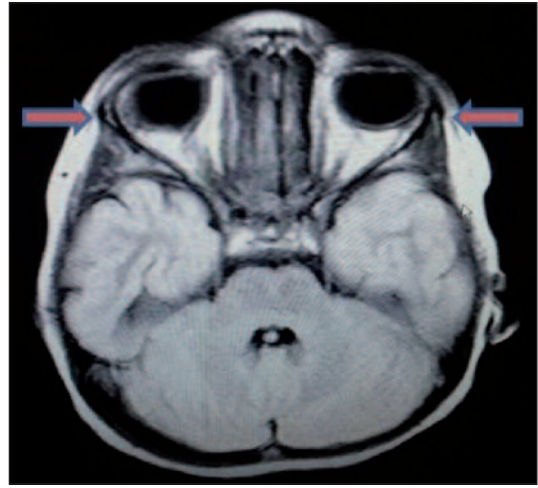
Orbital MRI shows bilateral hypoplastic lacrimal glands (red arrows).
